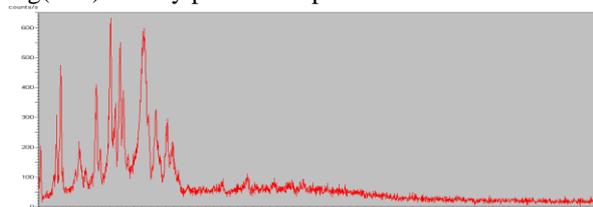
X-ray of solid dispersion of nimodipine and poloxamer 407 molar ratio (3:1).
